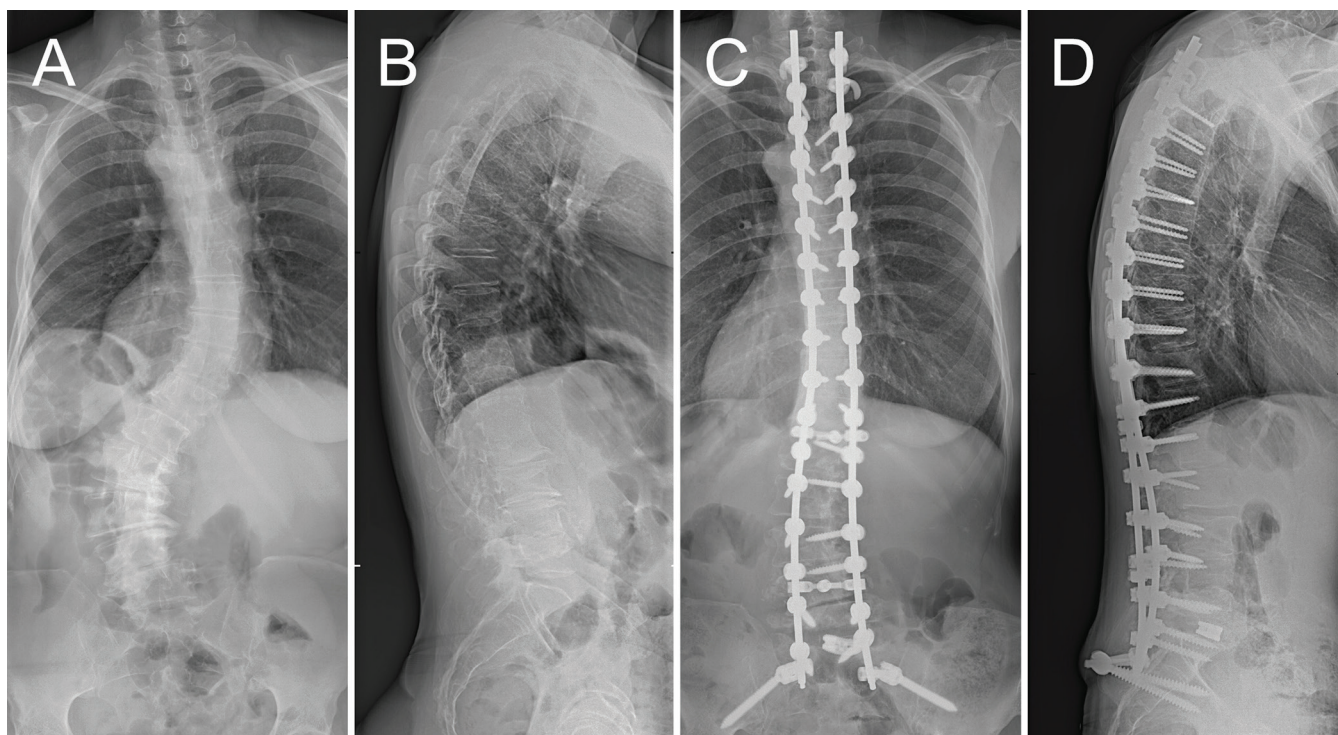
Revision Case No. 2: X-ray image of the patient's spine, anteroposterior (A) and lateral (B) before the surgery and anteroposterior (C) and lateral (D) after the surgery.
